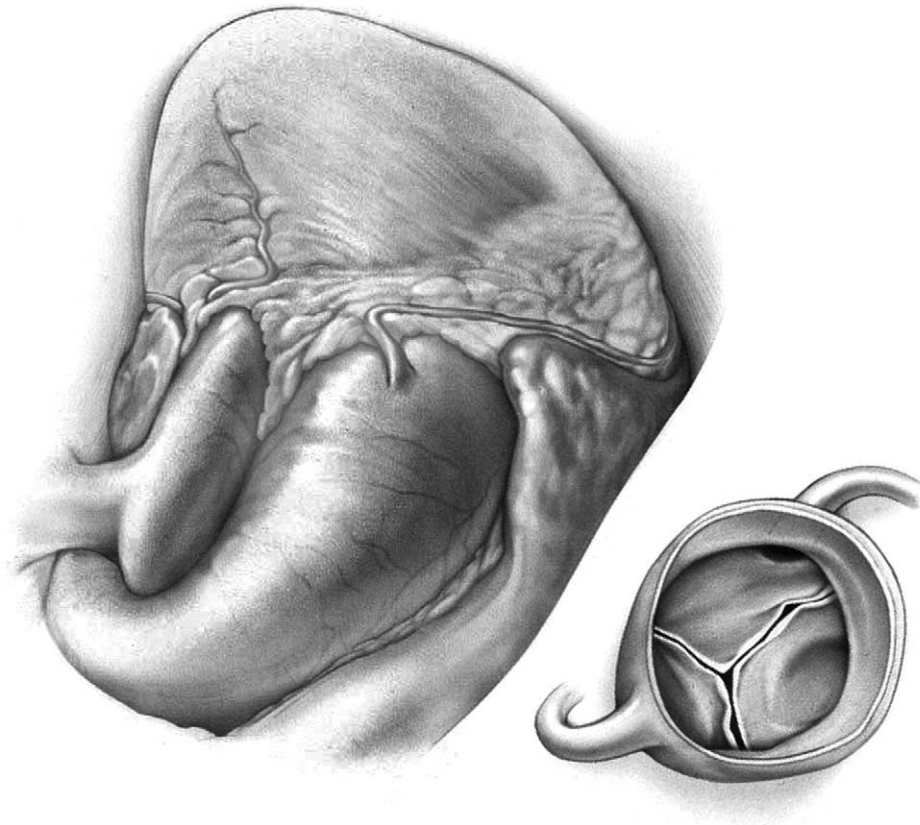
Standard full sternotomy is important for adequate exposure. Aprotinin and intraoperative transesophageal echocardiography are used routinely. We prefer to cannulate the aorta in the proximal arch rather than in the femoral vessels, even in patients with severe connective tissue disorders. Bicaval venous cannulation (in adults, two 24-Fr straight venous cannulae via the right atrial appendage and low right atrial wall) is our routine practice for two reasons. First, the SVC cannula holds the right atrial appendage down and inferiorly improves exposure of the root. Second, we routinely explore the right atrium for patent foramen ovale, which is present in one-third of patients and may be a risk factor for left heart endocarditis from paradoxical bacterial embolism. Caval snares are passed, and a left atrial vent is placed via the right superior pulmonary vein.
